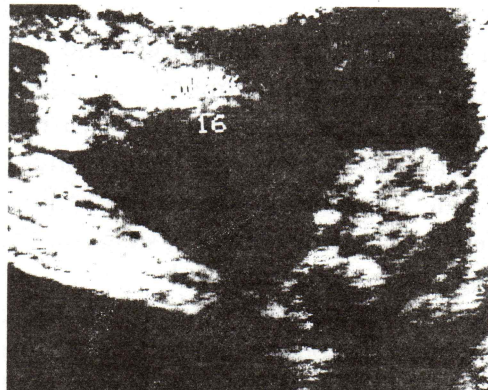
Transvaginal sonography demonstrates dilated posterior urethral valve and bladder due to posterior urethral valve obstruction at 11 weeks gestation.
